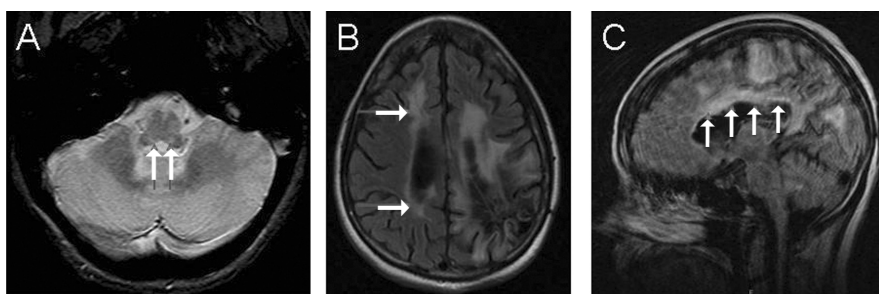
MRI studies of the brain showing white-matter lesions remote from region of left AVM encephalomalacia. A) T2-weighted axial view of the brain shows hyperintense signals in the brainstem, including dorsal lesions (arrows) accounting for bilateral INO demonstrated in Figure 1. B) FLAIR-weighted axial view showing right-sided periventricular lesions (arrows), in addition to extensive encephalomalacia from left AVM resection. C) FLAIR-weighted sagittal view showing hyperintensities along the corpus callosum (arrows), in addition to corpus callosum atrophy.
